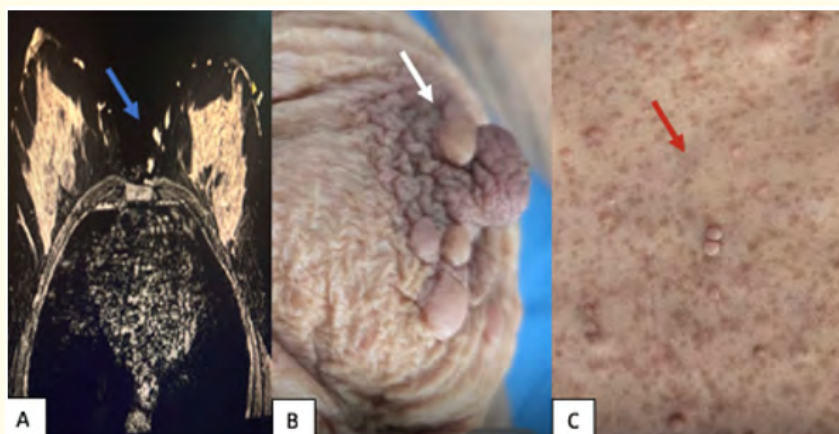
Breast MRI, axial T2-weighted sequence, showing a left breast neurofibroma with high T2 signal intensity (blue arrow) as well as multiple subcutaneous nodules also displaying high T2 signal (A). Clinical aspect of cutaneous neurofibromas visible on the chest (white arrow) in a patient with neurofibromatosis type 1 (B). Presence of multiple café-au-lait macules characteristic of neurofibromatosis type 1 (red arrow) (C).
